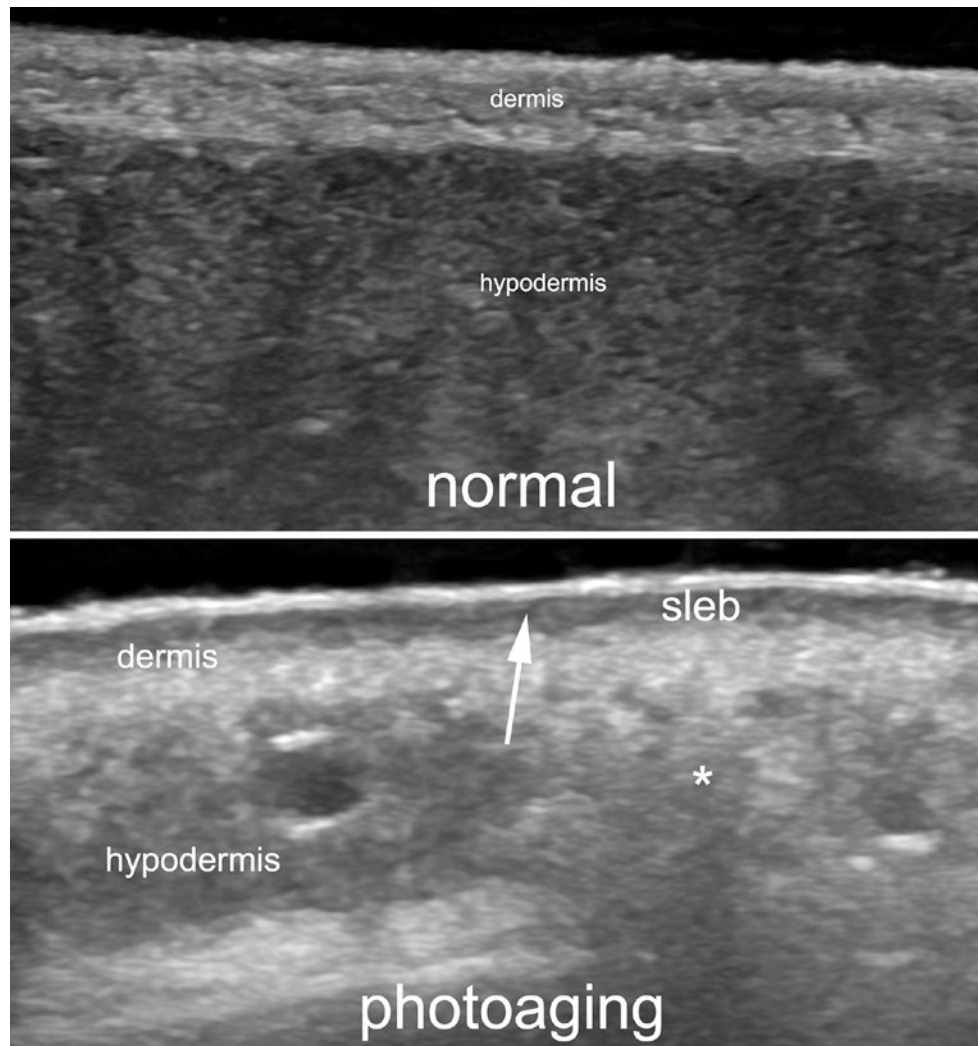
Photoaging. Comparative ultrasound views of the normal (left) and photoaged (right) dermis. Notice the subepidermal low echogenic band (sleb) in the upper dermis (*arrow*), and a hyperechoic deposit in the hypodermis that corresponds to silicone oil (*asterisk*).
